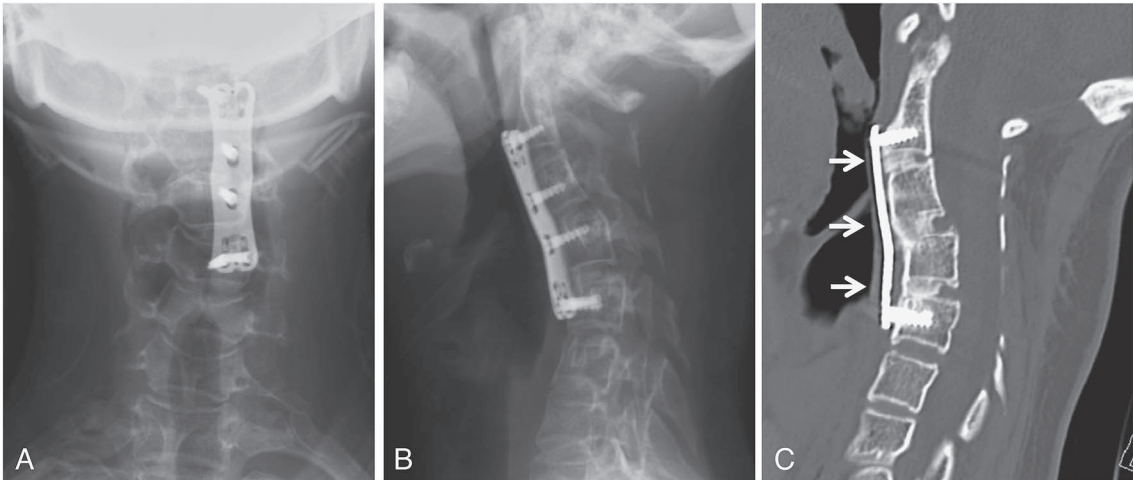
Plain radiographs and CT of the cervical spine 7 months after surgery. Anterior spinal fusion was performed with plates and screws from C2 to C5 (A, B). Computed tomography showed complete bony union between C2 and C5 (arrows) (C).
